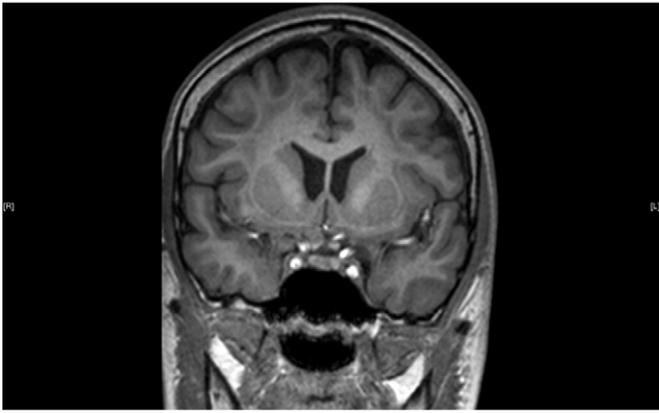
Coronal MRI section demonstrating thin bilateral laminar heterotopia.
